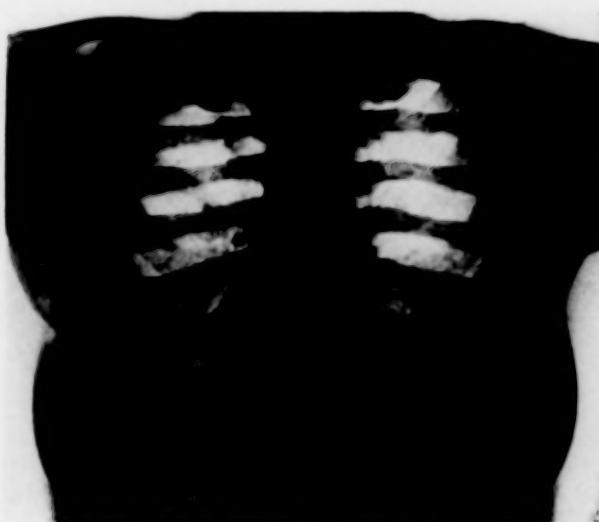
CASE I. Roentgenogram of chest. Note particularly the expanded anterior ends of ribs.
